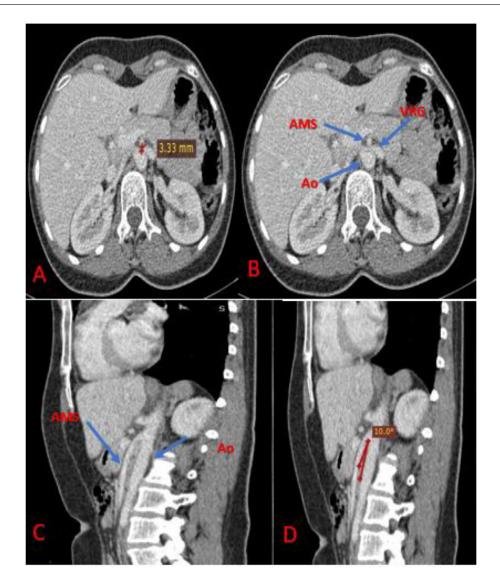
Case 1 Abdomino-pelvic CT scan with injection of PDC in sagittal and axial section showing compression of the left renal vein in the aorto-mesenteric space reduced to 3 mm with VRG stenosis of 73% (Figs. 1A and B). The sagittal reconstruction shows an aorto-mesenteric angle of 10° (Figs. 1C and D) AMS, Superior mesenteric artery; Ao, Aorta; VRG, Left renal vein; VOG, Left ovarian vein.
